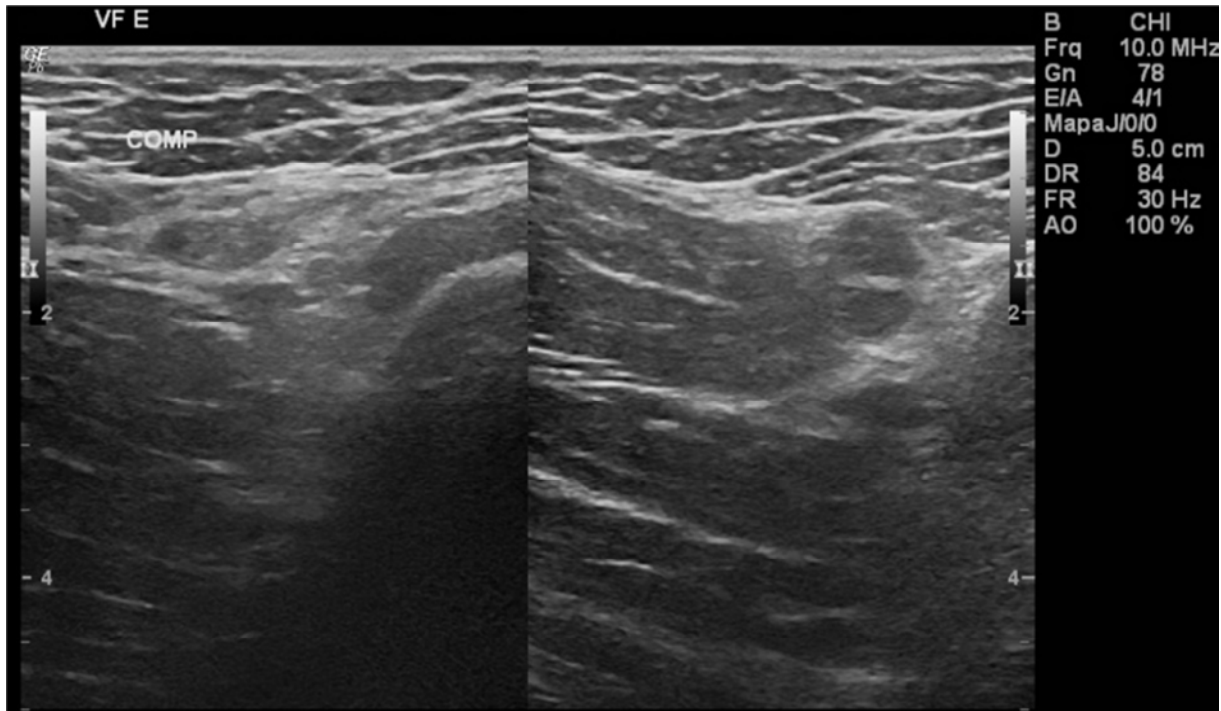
Doppler ultrasonography of the left lower limb demonstrating a thrombus in the left femoral vein.
